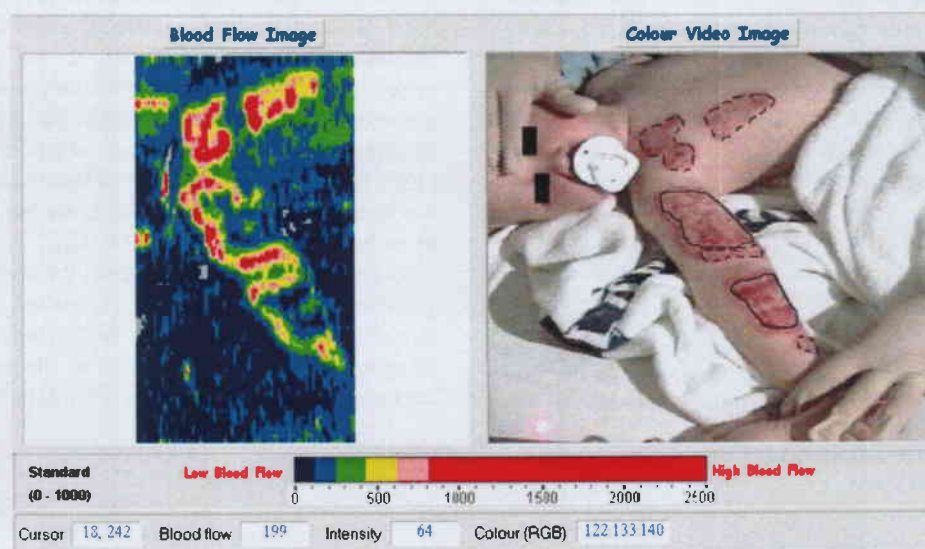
Example of moorLDI Laser Doppler report images. Patient identifying details have been deleted. Note quality of low-resolution colour digital image of burn. Deep burns outlined with solid black line, superficial burns with dashed line.
